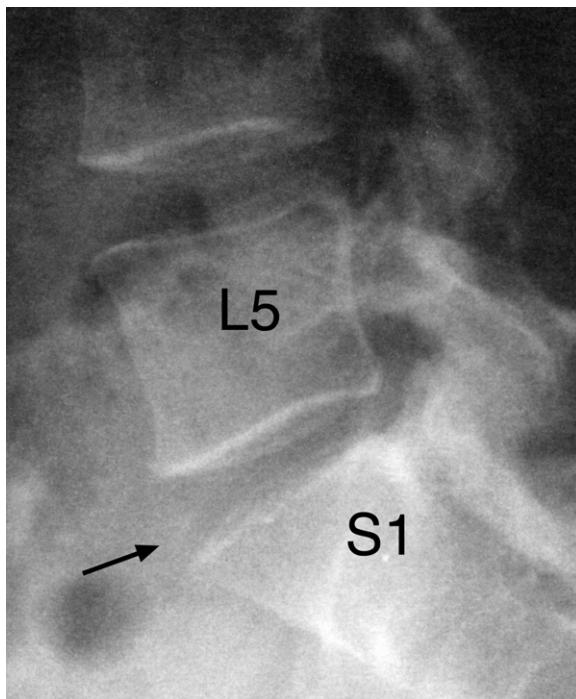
Lumbosacral spine lateral plain X-ray image. Note the thinning of the L5–S1 intervertebral disc space height (arrow) with retrolisthesis of L5 on S1 strongly suggesting a posterior disc bulge or protrusion.
